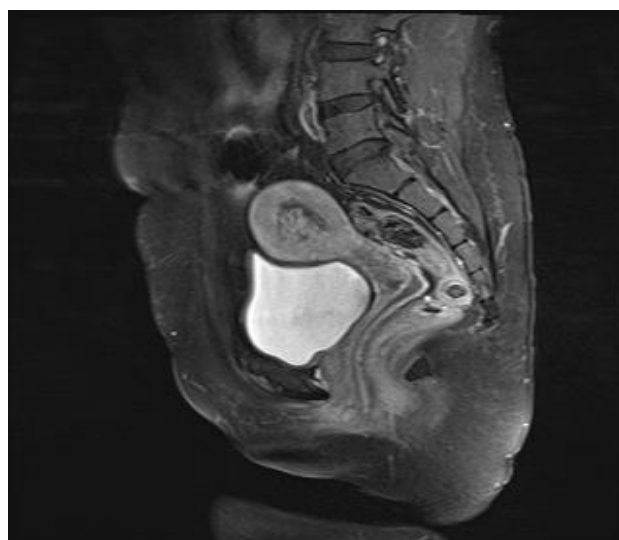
Sagittal T1 weighted post contrast fat saturated image of MRI pelvis showing the tortuous vascular channels in endometrial cavity.
